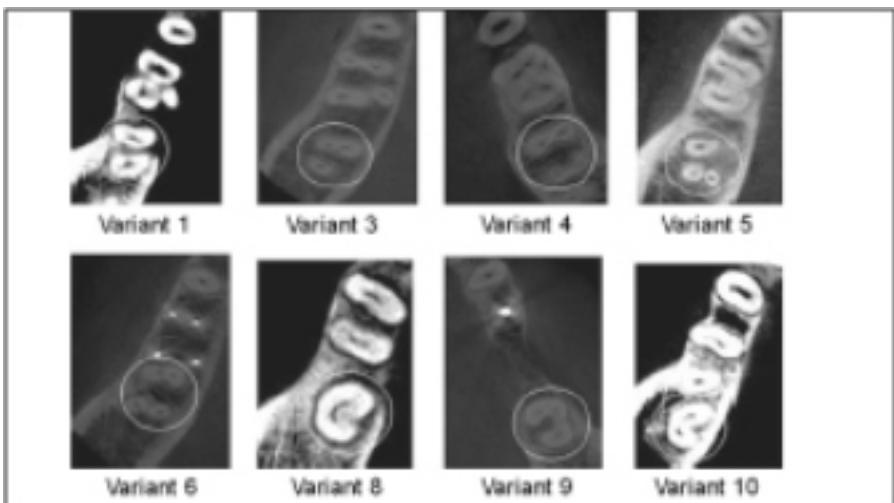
Cone-beam computed tomography images showing the categorisation of the eight variants in mandibular second molars found . The white circles indicate the examined tooth.
